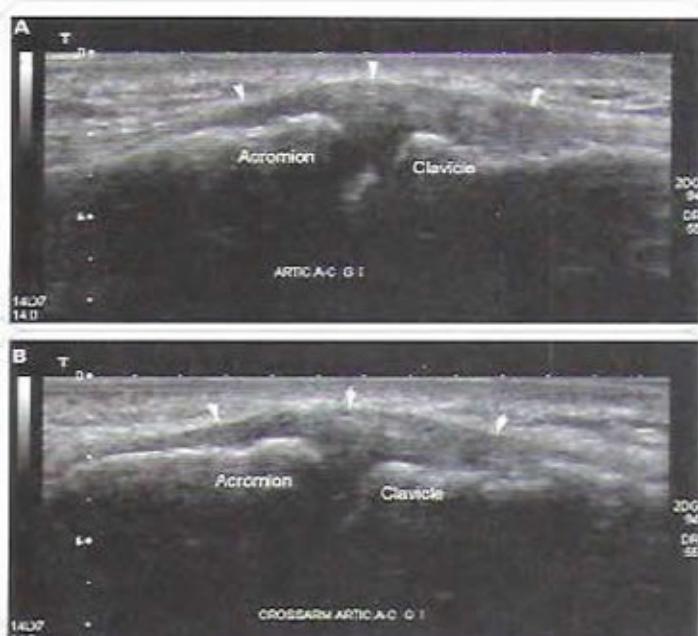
AC joint sprain. Sonogram shows bulging of the capsule (arrowheads) with contact between bony structures (arrow) during the cross-arm maneuver suggestive of injury to the articular disc.
